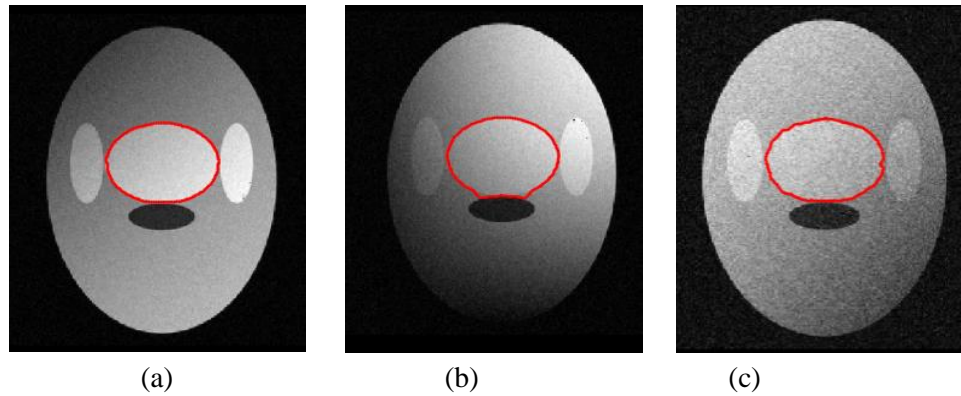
PLCSF results on synthetic MRI slices (red outline). Notice that even in presence of noise, IIH and low contrast between tumour and background, the PLCSF obtained accurate outline of a tumour region.
